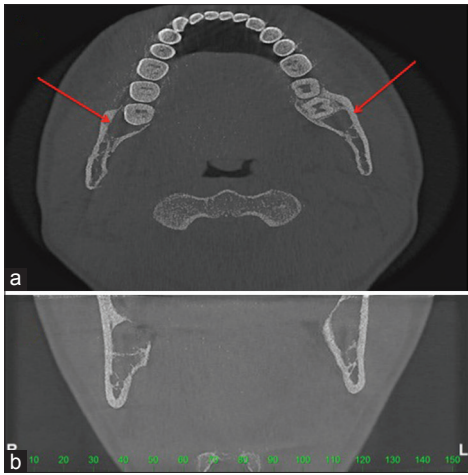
Cone beam computed tomography axial view showing a well unilocular lesion (arrows) with a thin radiopaque border bilaterally (a); coronal view of low density corticated in the molar area
